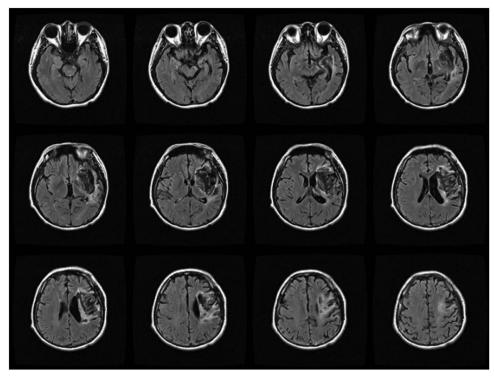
T2-weighted MRI images for patient Y.Q. The right side of each image refers to the left hemisphere. The patient had severe lesions in the left frontotemporal lobe and basal ganglia due to cerebral infarction. No obvious lesions were found in the parietal lobes.
